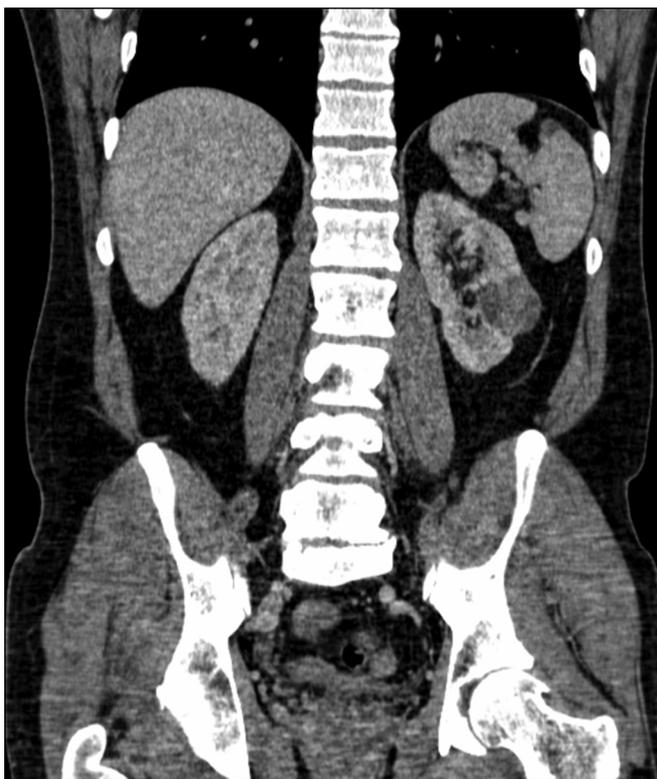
Computed tomography scan showing enhancing multicystic renal mass.
